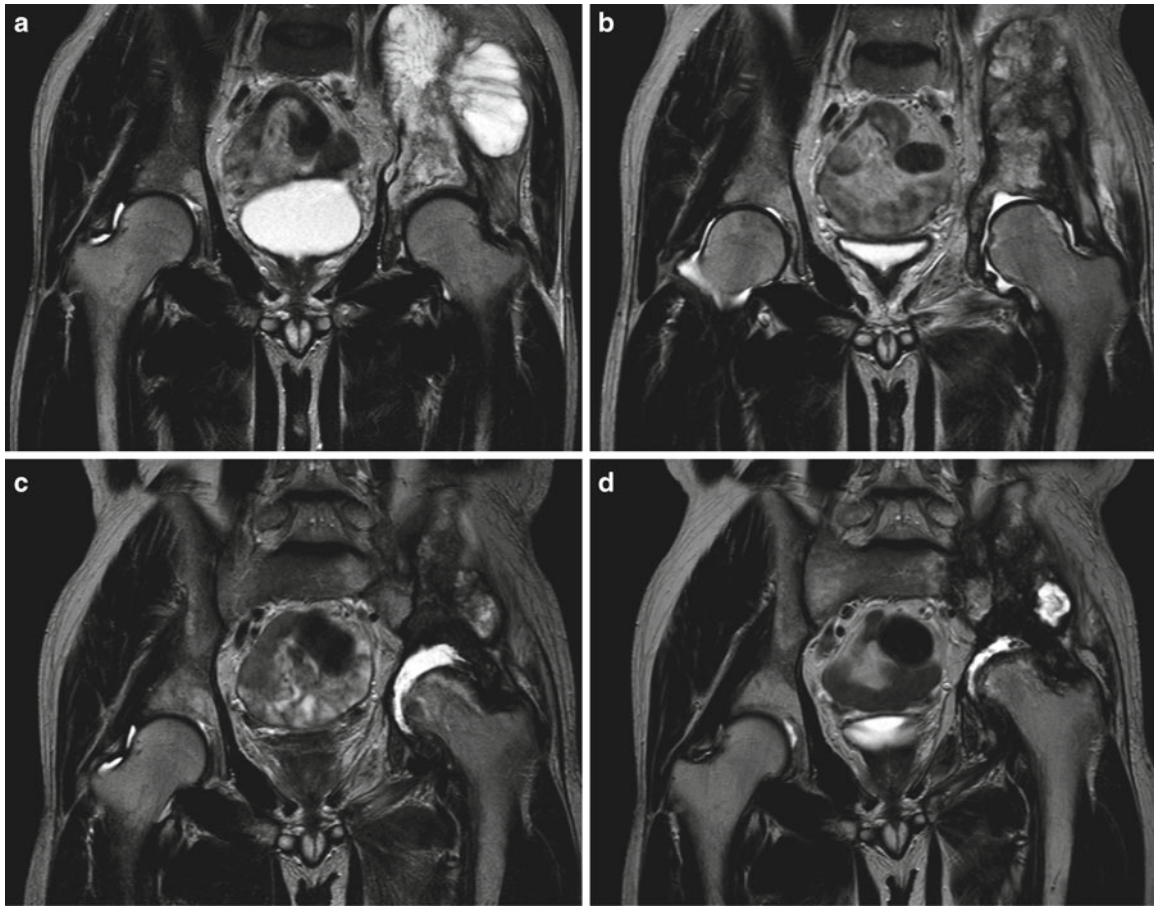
Destruction of the acetabulum and the femoral head over time, after carbon ion radiotherapy. (a) T2-weighted coronal MRI before carbon ion radiotherapy (b) T2-weighted coronal MRI 1 year later. (c)
